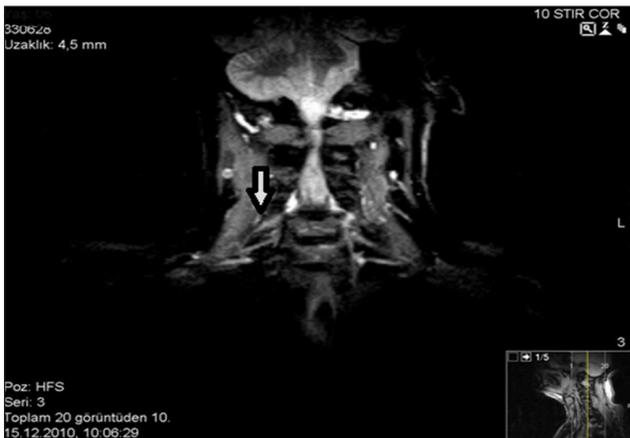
In coronal plane of STIR sequence MRI, there is increased thickness at the middle trunk level of right brachial plexus.
